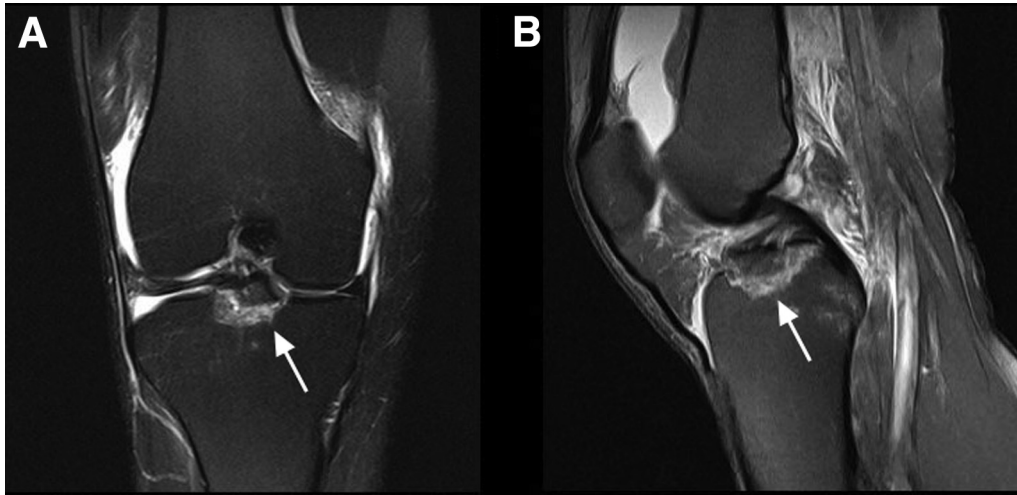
Preoperative (A) anteroposterior and (B) lateral magnetic resonance imaging scans of the right knee showing a displaced tibial spine avulsion of the anterior cruciate ligament (arrows).
